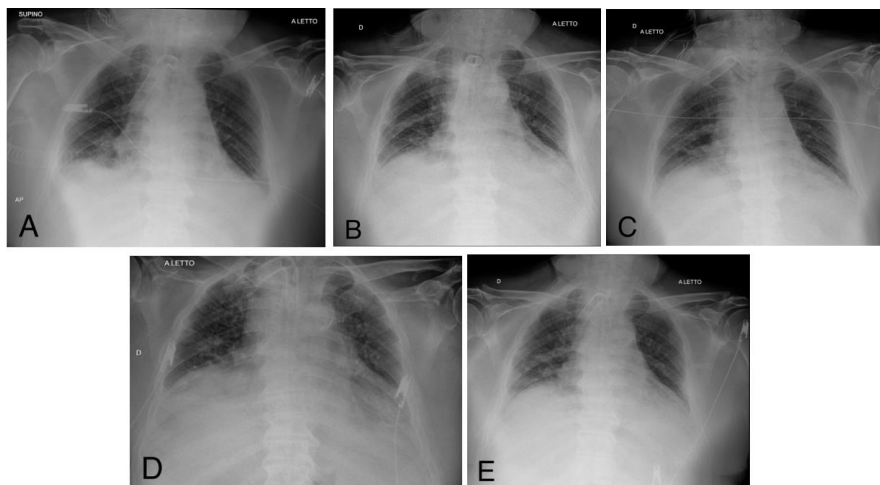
Chest X-ray sequence: June 8 (A); June 13 (B); June 15 (C); June 17 (D); June 18, 2023 (E), that shows a blurred and inhomogeneous parallel and basal right thickening; a minimal layer of ipsilateral pleural effusion and enlarged cardiomeastinal shadow and tracheostomy.
